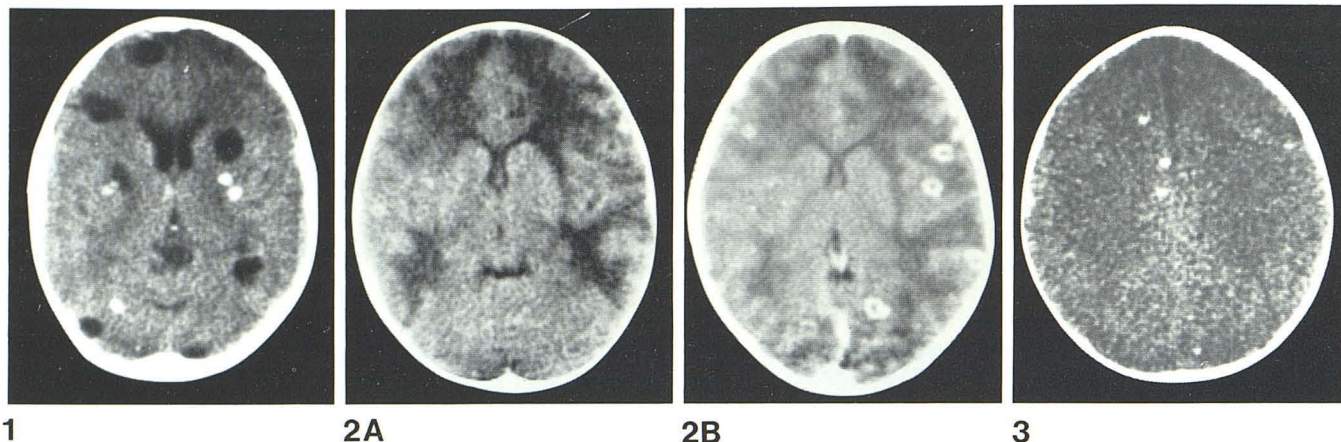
24-year-old black man with 2 year history of convulsions. This CT slice shows old calcified granulomata and six nonenhancing cysts, which represent old and recent episodes of larval infestation.
